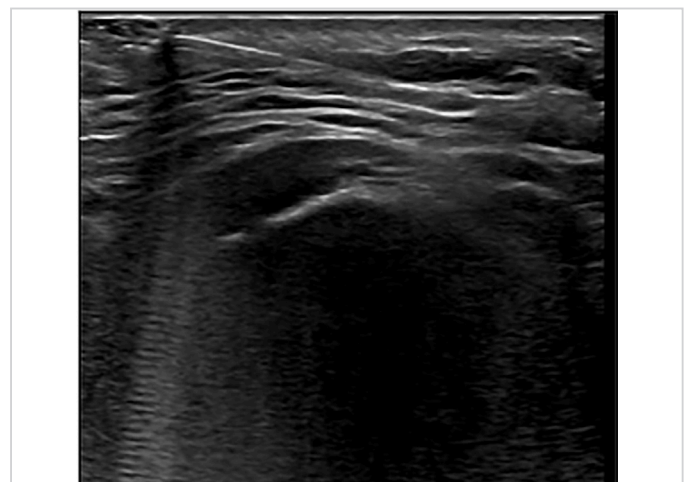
Ultrasound of the neck done prior to removal of fishhook showing the sharp foreign body penetrating in the subcutaneous plane with its tip inside
